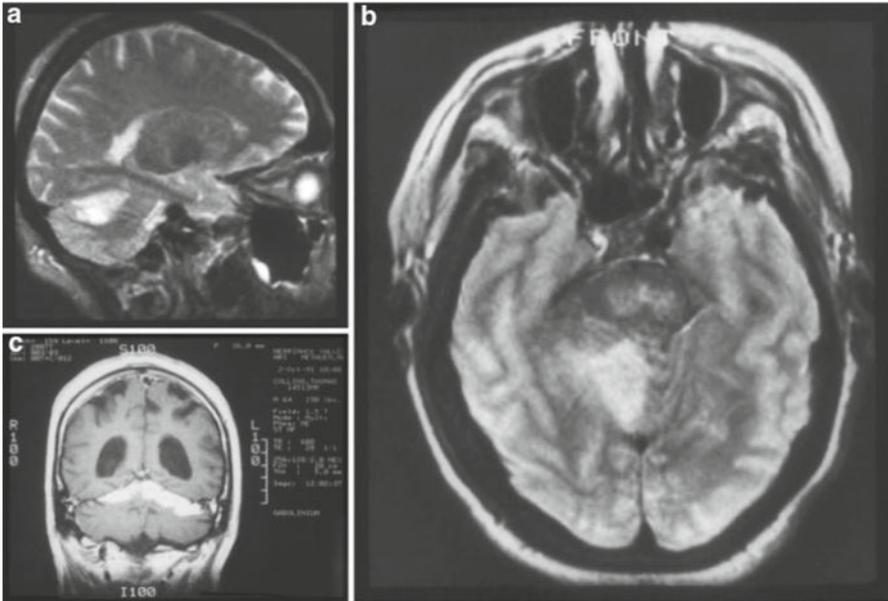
MRI T2-weighted scans (From Caplan 1996). (a) Sagittal view showing SCA territory infarct. (b) Axial section showing small vermian cerebellar infarct in the territory of the medial branch of the superior cerebellar artery (*mSCA*). (c) Coronal section showing a bilateral SCA territory infarct appearing like “icing on a cake”
